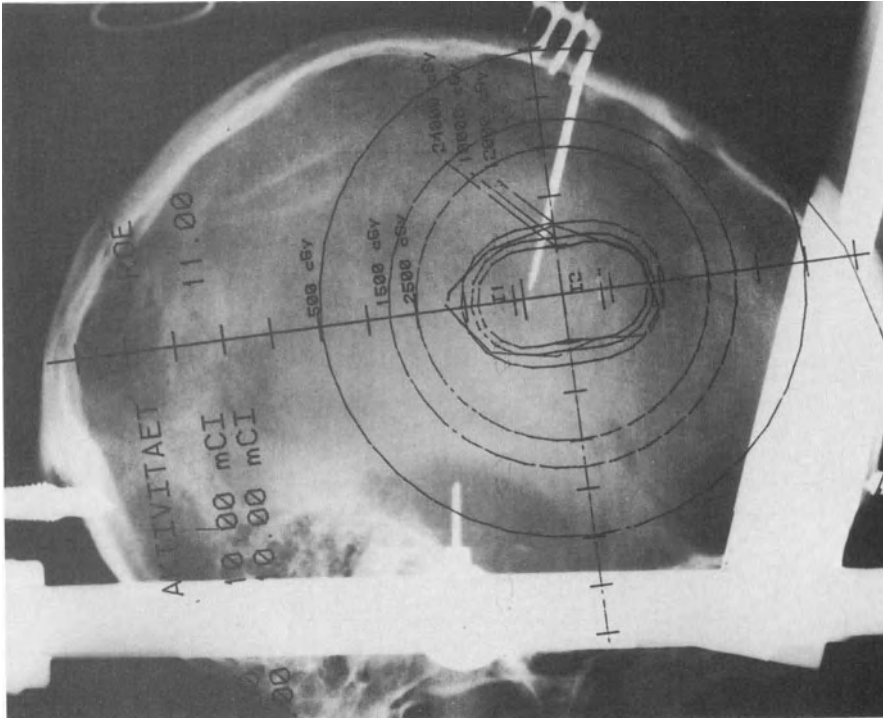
The computer-calculated isodose curves are transposed onto the roentgenogram.
